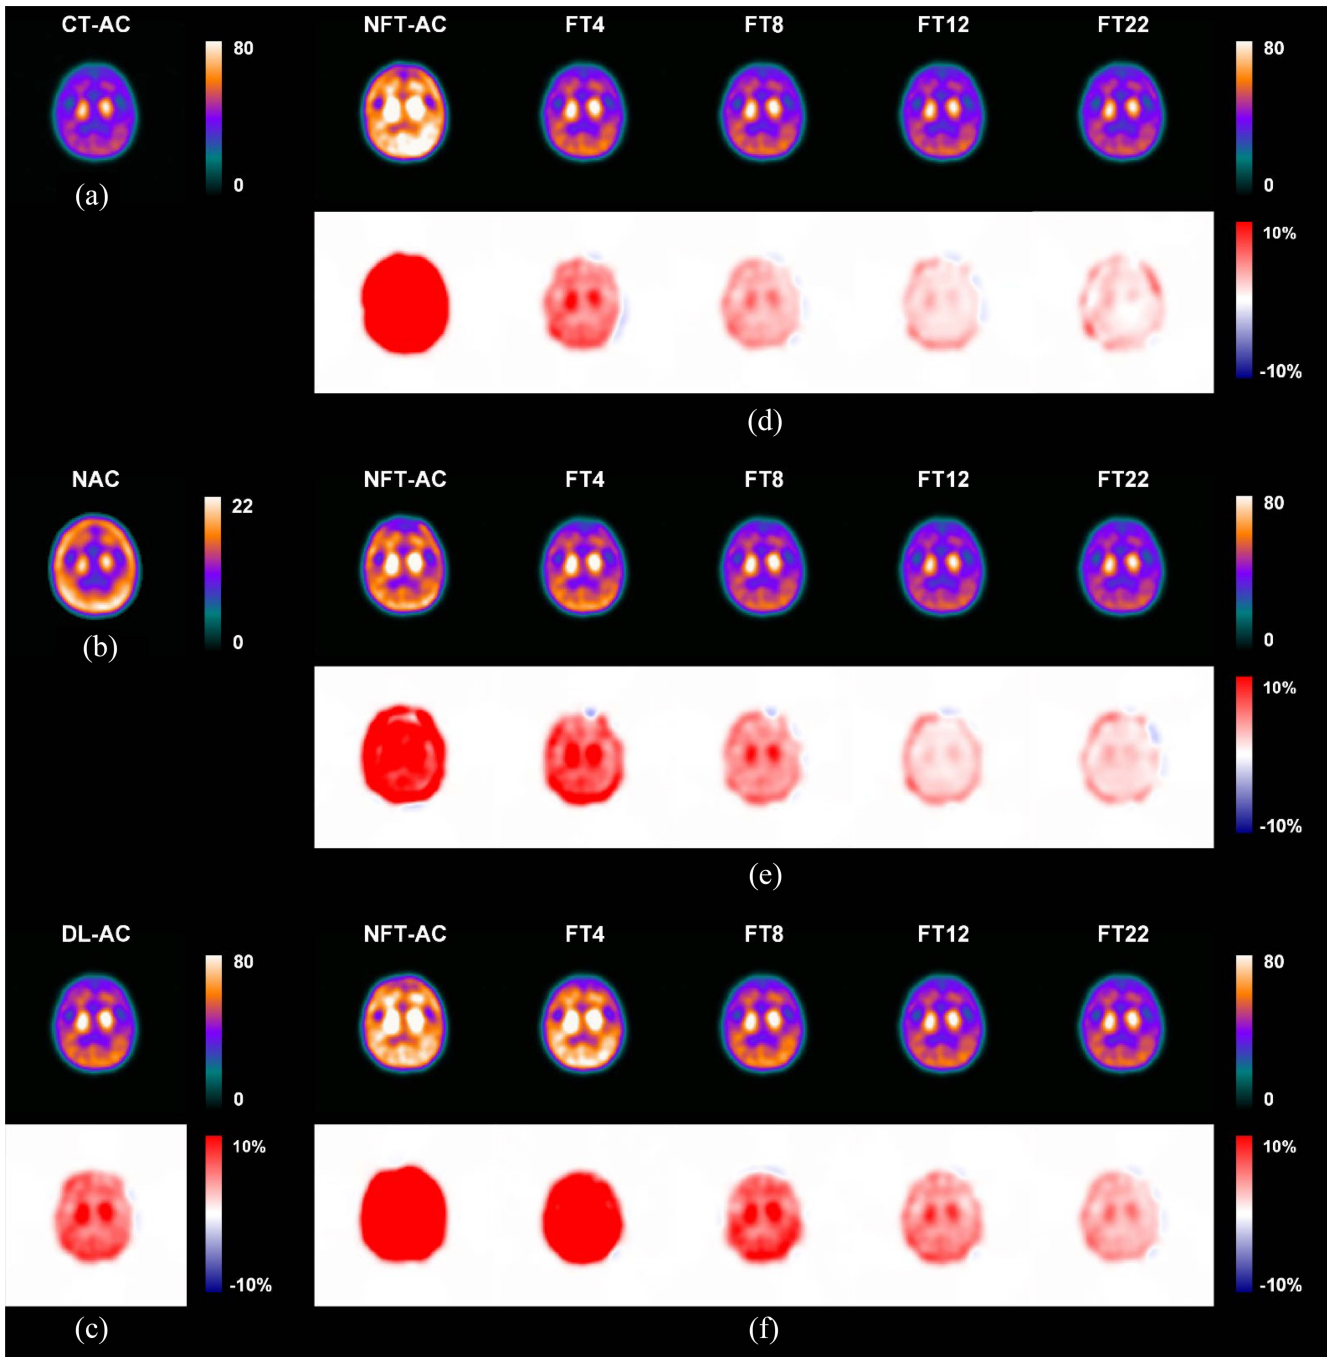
Representative results of an 80-year-old female patient. Sample axial SPECT images of (a) CT-AC, (b) NAC, (c) DL-AC, NFT-AC, and FT-AC methods with different numbers of FT data for the tested S-TRODAT-1 data using (d) S-ECD (cross-tracer), (e) G-TRODAT-1 (cross-scanner), and (f) G-ECD (cross-tracer+cross-scanner) as the pretrained network. The corresponding error map as compared to CT-AC is shown under each SPECT image, respectively.
